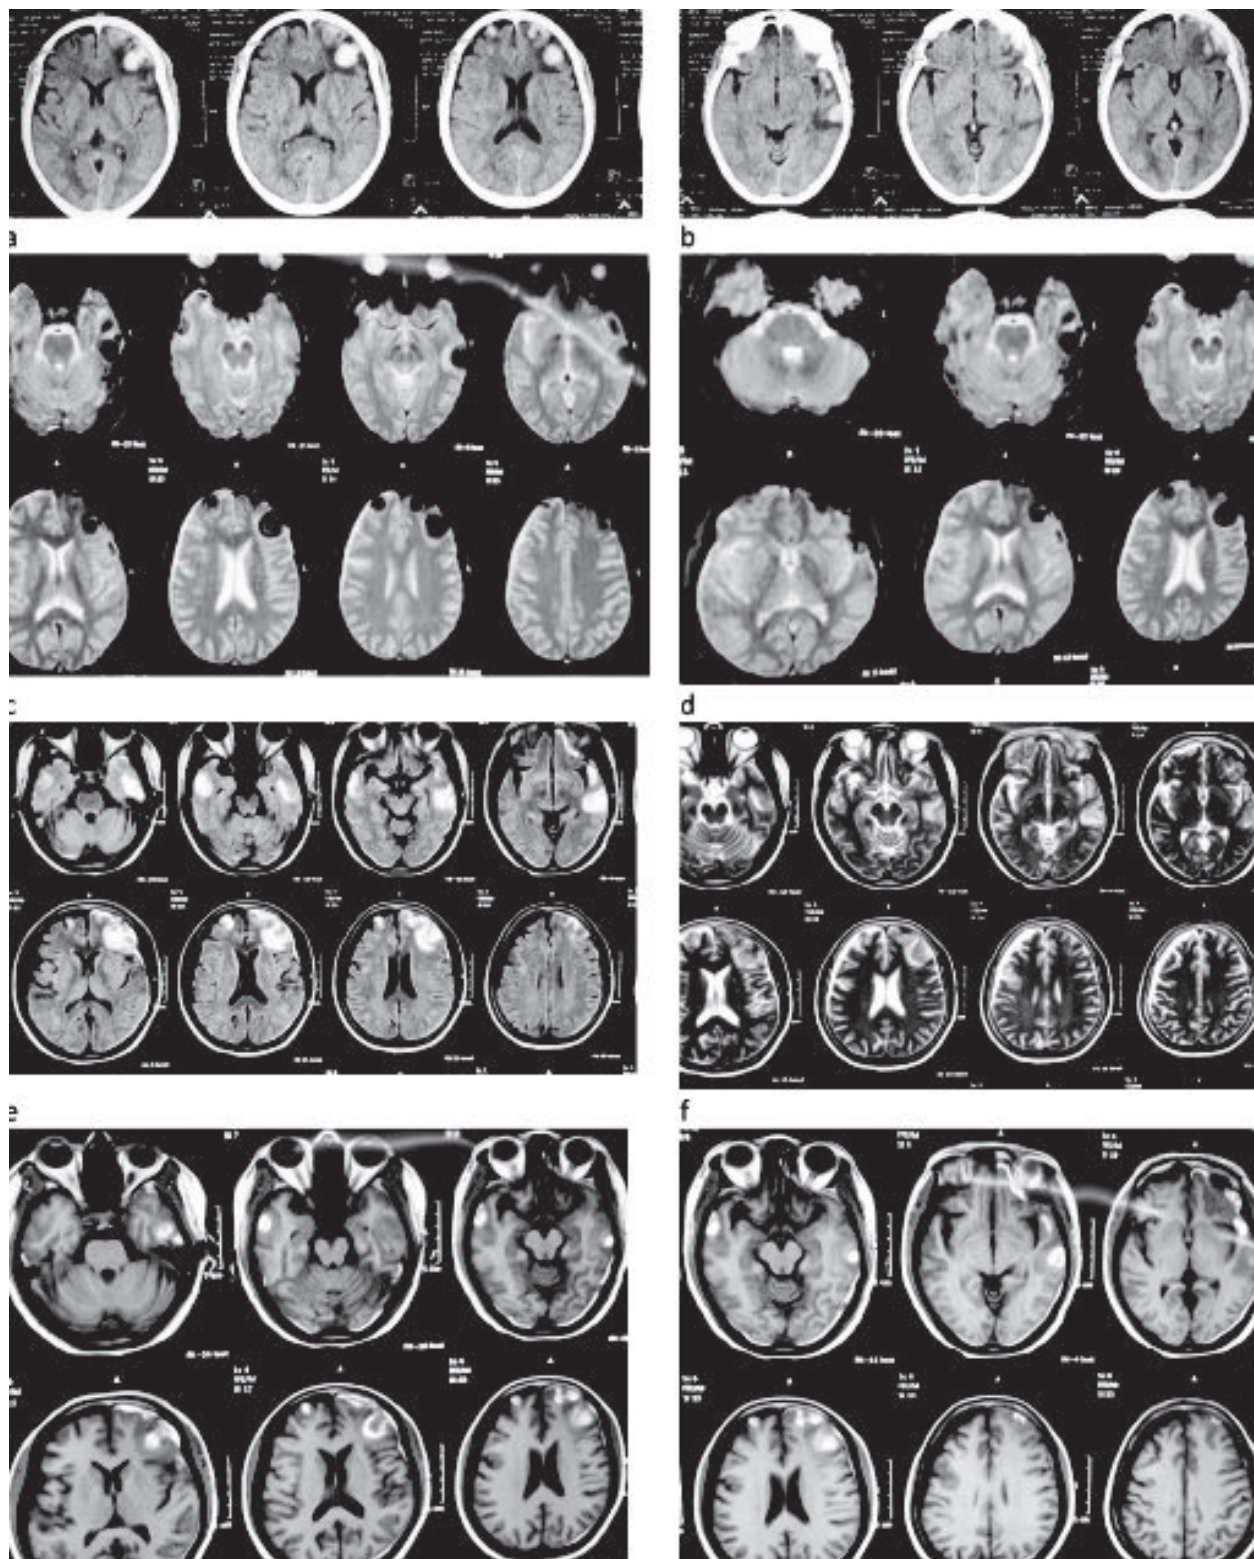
Image of the brain of the patient. (a) Ct head hemorrhage in the right and left frontal lobe (b) CT head hemorrhage in the left temporal region (c,d) MIR of the brain, GRE sequence hypointense lesion in both frontotemporal region (e) FLAIR sequence hyperintense lesion in the both frontotemporal region (f) T2 sequence, hyperintense lesion in the right frontal lobe (g,h) T1 sequence hyperintense lesion in both frontotemporal region
